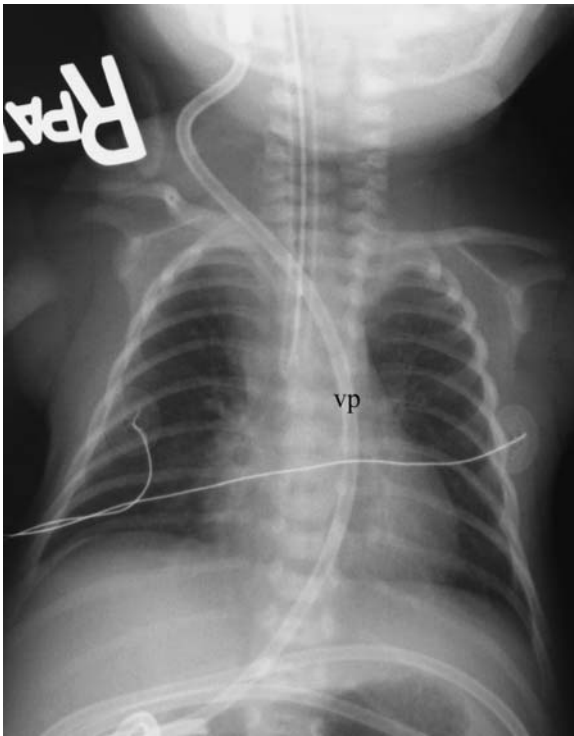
Chest radiograph in a newborn with respiratory distress
